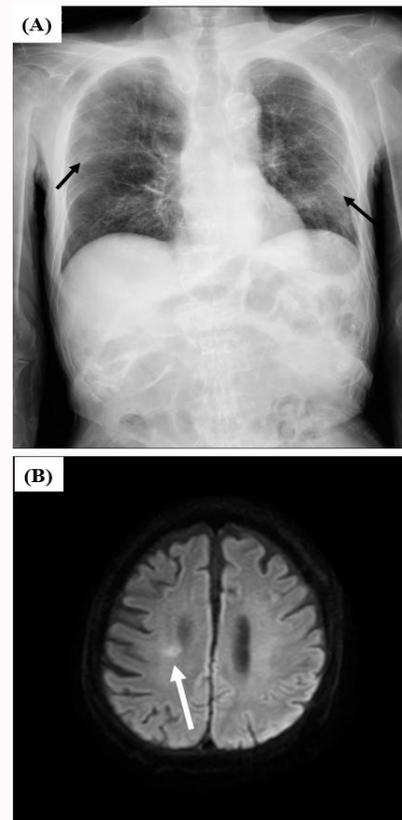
Chest X-ray (A) and brain MRI (B) of the case 3 patient on admission. Interstitial shadows are seen in both lung fields (A), and infarction is found in his right brain (B). Arrows indicate the abnormal shadows on chest X-ray and brain CT, such as interstitial shadows in the lungs and the infarction site in the brain.
